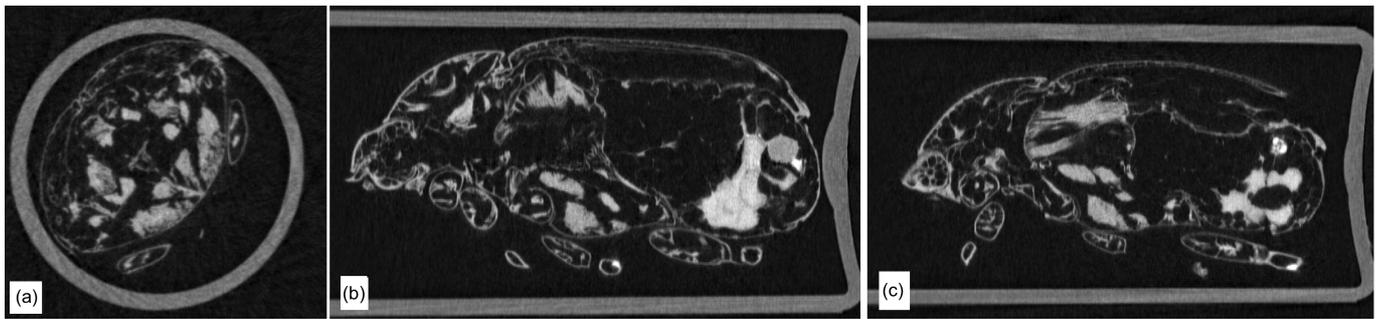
laboratory based, single-shot phase CT of a bug – (a) shows an axial slice, (b) and (c) two different sagittal re-slices. Despite having been collected in approximately 5’, phase effects clearly show the soft tissue details inside the insect’s body.
